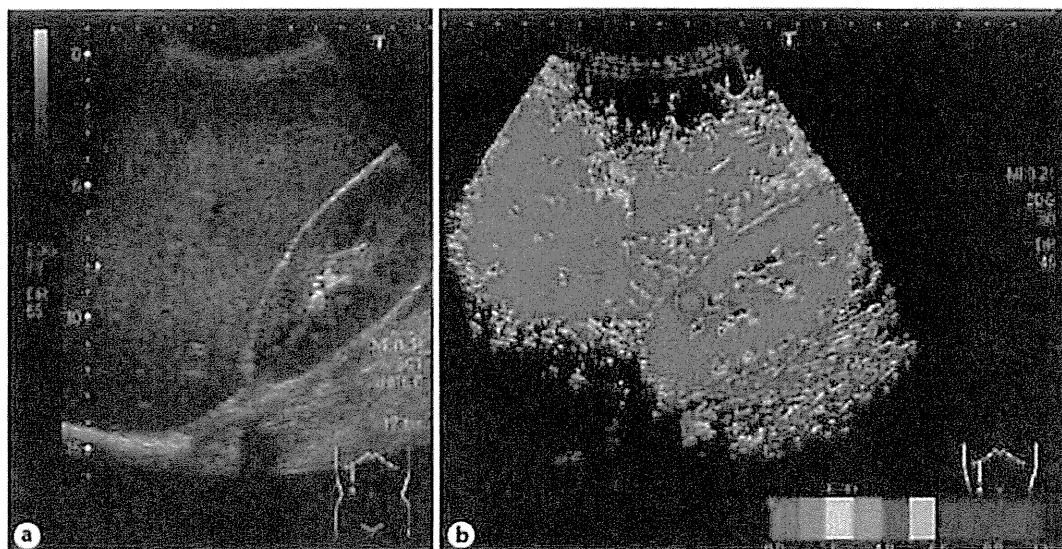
Ultrasound images of case 2 taken in March 2010. a B-mode ultrasound image. b Arrival time parametric image. Red, indicative of early arrival, dominated the entire area of the arrival time parametric image of the liver.
